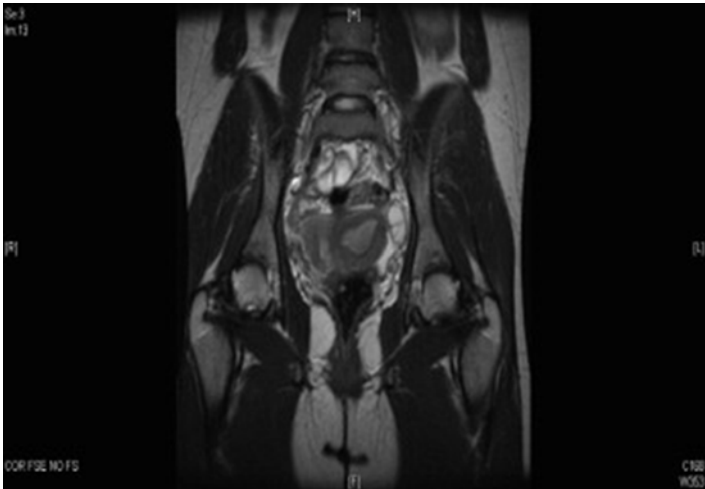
MRI indicating significant myometrial connection between unicornuate uterus and functional, noncommunicating uterine horn (Reprinted from Spitzer et al. [37], with permission from Elsevier and the North American Society for Pediatric and Adolescent Gynecology)
